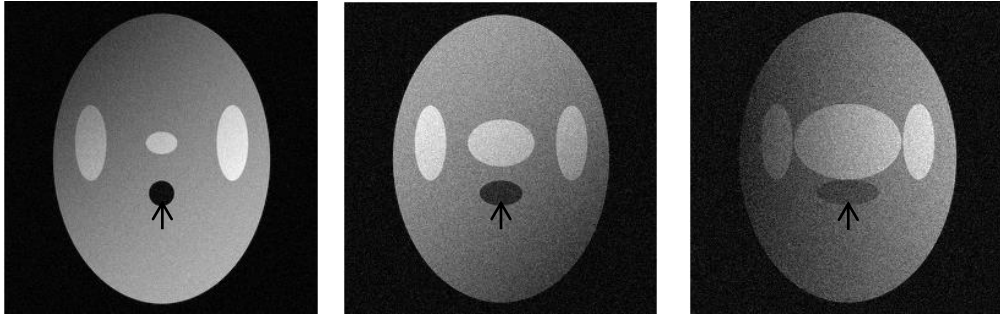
Example of MRI slices from synthetic MRI volumes with addition of MRI artefacts (black arrow indicate the throat region as low intensity ellipses of varying sizes)
